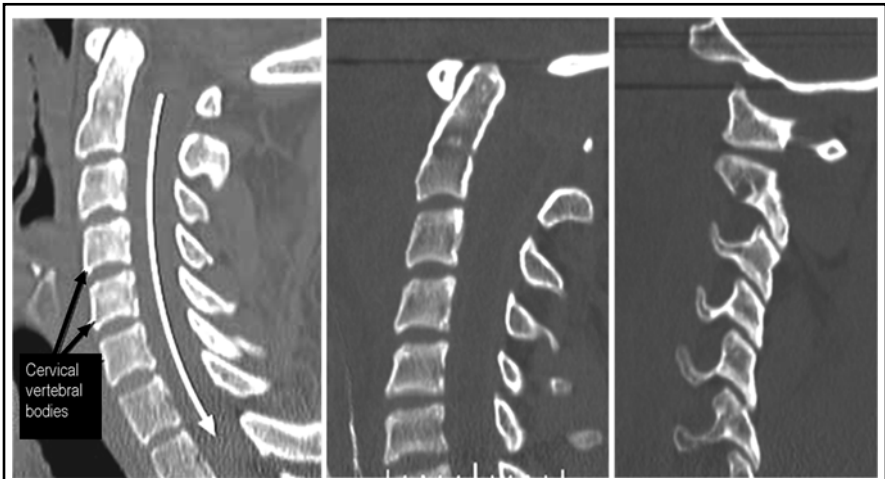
CERVICAL SPINE CT SAGITTAL VIEWS
